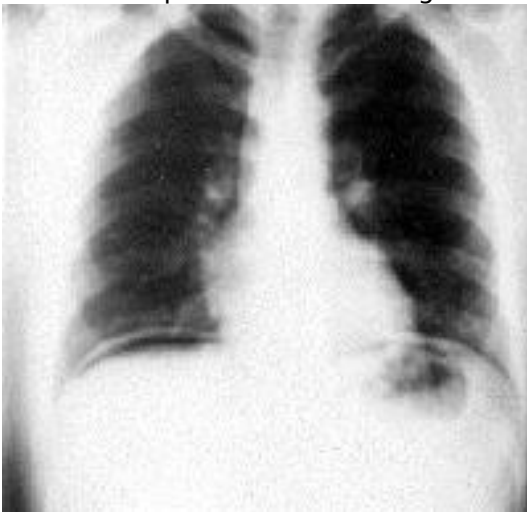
X-Ray examination of abdominal cavity, pneumoperitoneum
